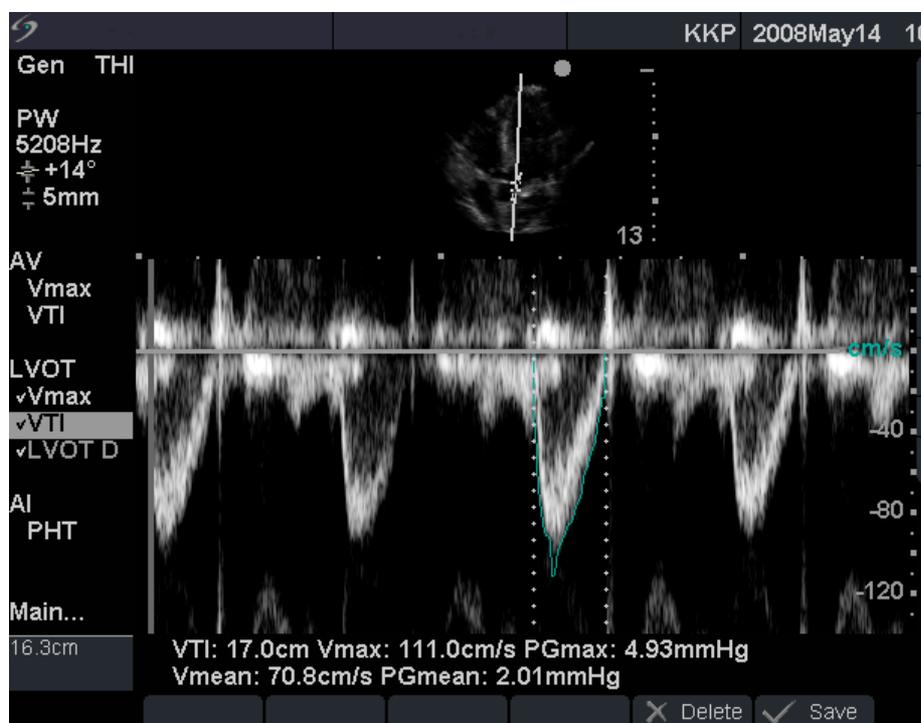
An example of Pulsed Wave Doppler of normal flow through the left ventricular outflow tract
